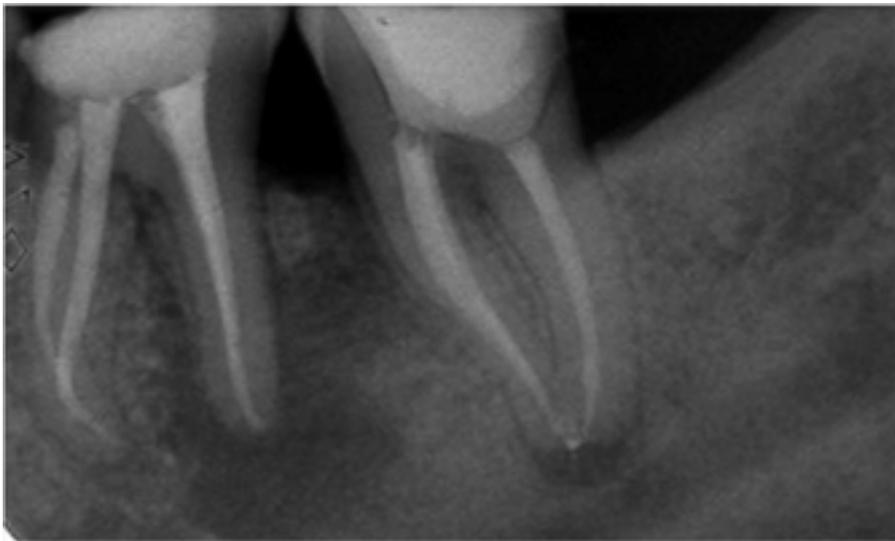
Post-operative X-ray of teeth 3.6 and 3.7.
